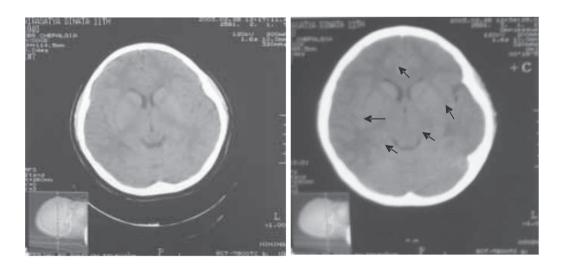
First head CT scan showed small hyperdense areas on the frontal, right and left parietal regions (left), which was also enhanced with contrast (right)
